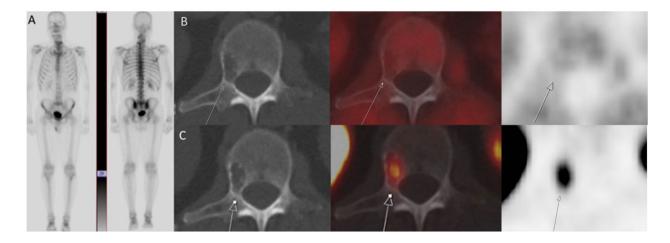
A: 99mTc-MDP bone scintigraphy revealed no abnormal tracer uptake in the skeleton. B: 18 F-Fluciclovine PET, CT, and fused PET/CT images demonstrated no abnormal tracer uptake within the geographic lytic lesion at L1. C: PSMA PET, CT, and fused PET/CT images demonstrate the L1 lytic vertebral lesion, stable in size and appearance, while exhibiting intense avidity
